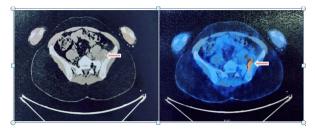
PET-CT FUSION study revealing a well-defined lesion with minimal metabolic activity within the substance of left iliacus muscle with fusiform extension into the left sacroiliac joint
